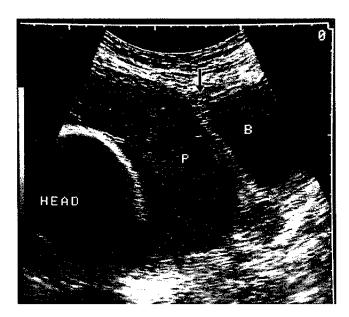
Ultrasound scan of major anterior placenta praevia at 38 weeks showing uterovesical angle (arrow), bladder (B), placenta (P) and fetal head.
